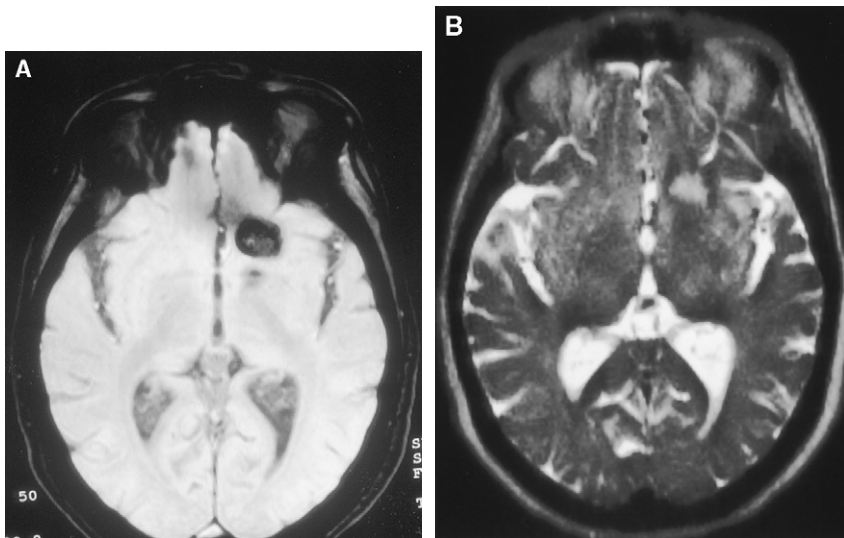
Cavernous malformation (CM). (a) There are two lesions in the left frontal lobe and internal capsule with hemosiderin rings, compatible with CMs on the gradient-echo image. Note that on the fast spin-echo T2-weighted image, the smaller CM is not seen and it is impossible to identify the hemosiderin deposition associated with the larger CM.
